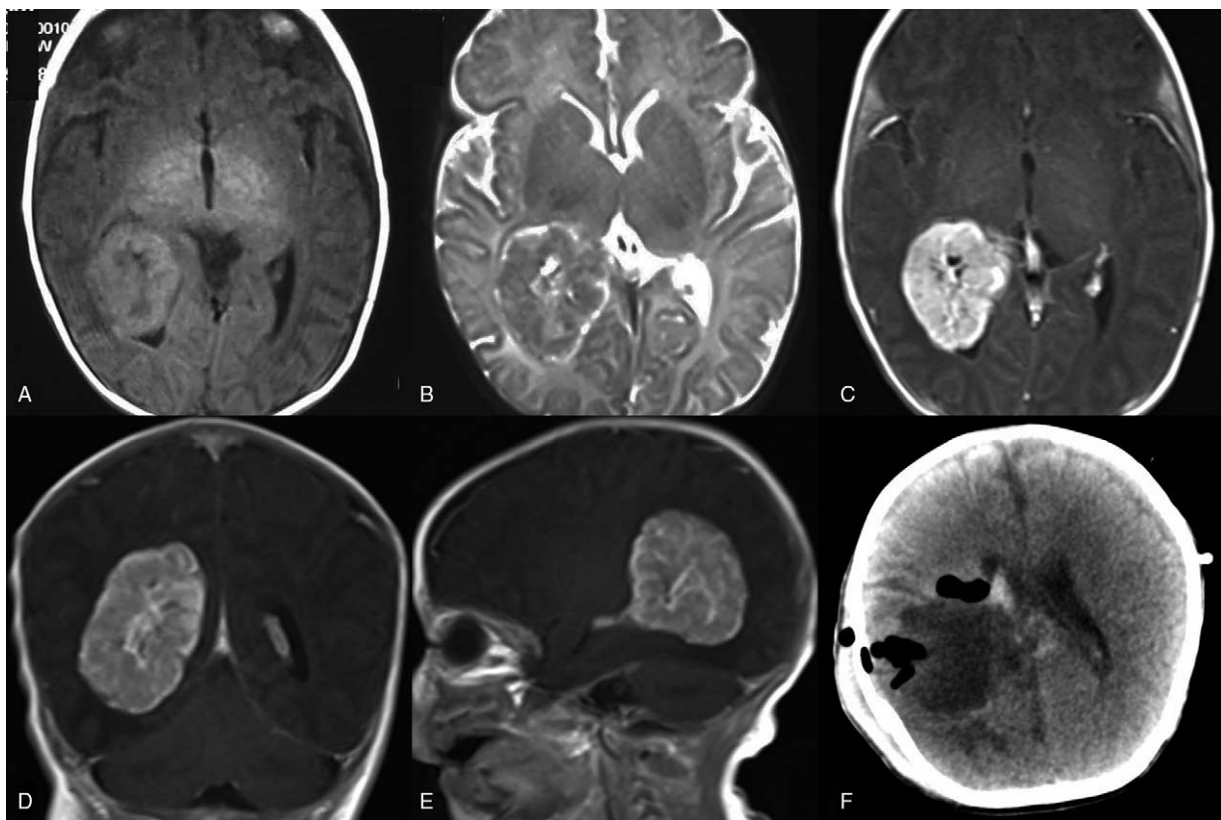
Images for patient 1. (A) Preoperative T1-weighted magnetic resonance imaging (MRI) showing the mass in the right lateral ventricle. (B) Preoperative T2-weighted MRI showing cerebrospinal fluid surrounding the tumor. (C) Postcontrast T1-weighted MRI showing heterogeneous enhancement of the tumor. (D) Coronal section of the tumor. (E) Sagittal section of the tumor. (F) Postoperative computed tomography (CT) of the patient showing complete resection of lesion. CT=computed tomography, MRI=magnetic resonance imaging.
